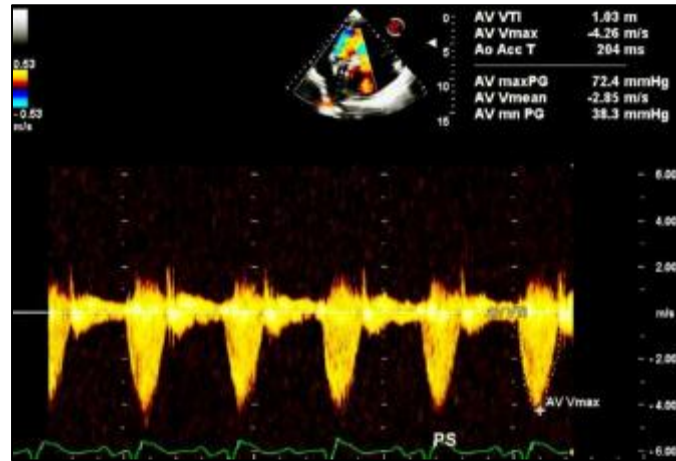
On continuous wave doppler (CWD) analysis across the pulmonary valve a CWD signal of severe pulmonary stenosis is displayed with a peak and mean gradient of 72.3/ 38.3 mmHg
